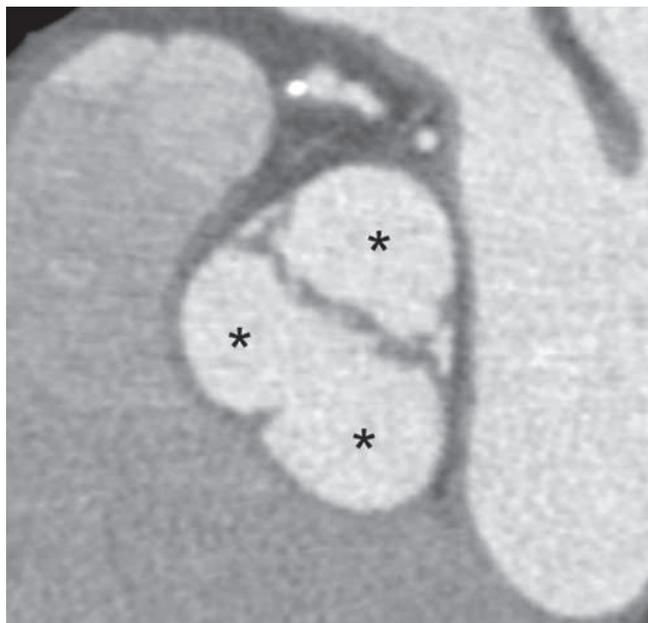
A 52-year-old man with an acquired functionally bicuspid valve. The cross-sectional reformatted contrast-enhanced CT image reveals three sinuses of Valsalva (asterisk), but only two cusps. This functionally bicuspid appearance can be the end result of fusion between two cusps, in this case secondary to a decade-old valve infection. As such, originally tricuspid aortic valves can become functionally bicuspid.
